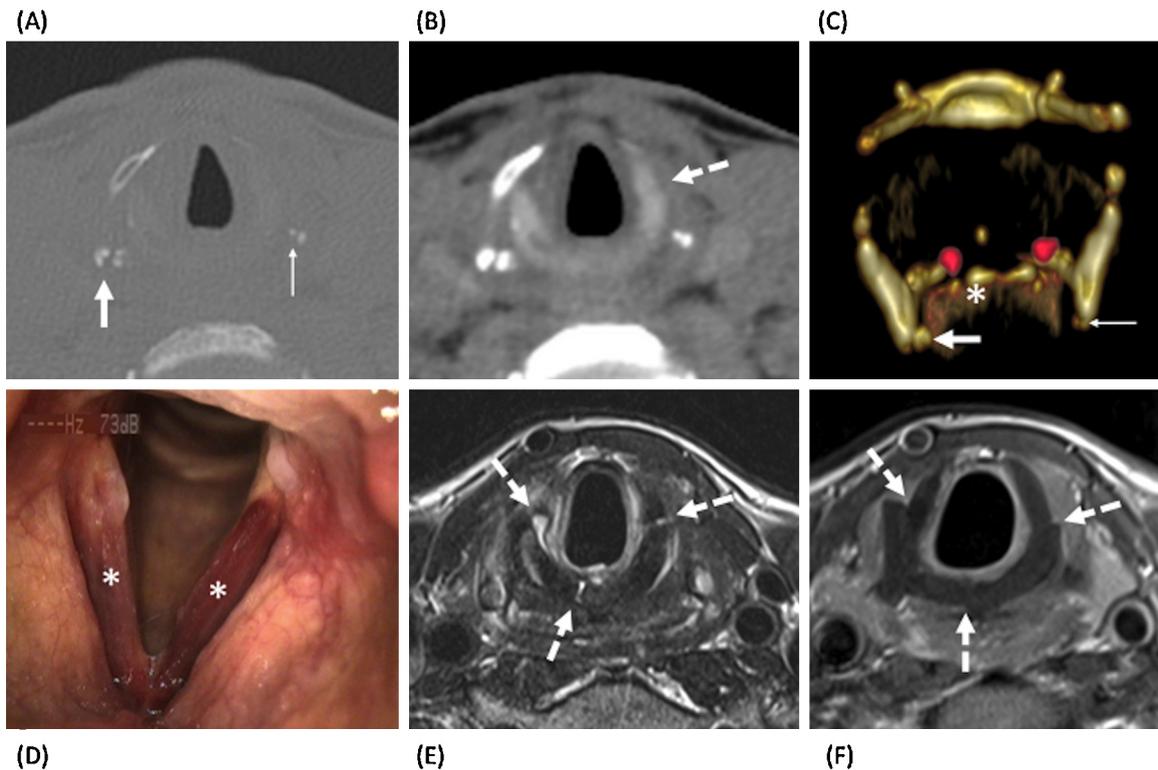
Cricoid cartilage fracture suspected on CT and confirmed on MRI in a young female who fell on the stairs. (A) Axial bone window at the level of the subglottis shows bilateral fractures of the inferior horns of the thyroid cartilage (right fracture: thick arrow; left fracture: thin arrow). The cricoid cartilage cannot be assessed on this axial bone window. (B) Corresponding axial soft tissue window reveals a possible fracture line in the left cricoid cartilage (dashed arrow). (C) 3D VR (posterior view) depicts the hyoid bone, thyroid cartilage and cricoid cartilage in beige and the arytenoids in red. Fracture of the left inferior horn (thick arrow) and right inferior horn (thin arrow) of the thyroid cartilage. Note that the cricoid cartilage (asterisk) is poorly ossified and a fracture of the cricoid cannot be seen. (D) Flexible endoscopy shows bilateral glottic (asterisk) and subglottic hematoma and no mucosal laceration. T2w image (E) and T1w image after intravenous gadolinium (F) obtained at the same level as in (A and B) clearly show three fracture lines within the nonossified cricoid cartilage (dashed arrows). There is slight fragment displacement on the right, however the subglottic mucosa appears intact.
